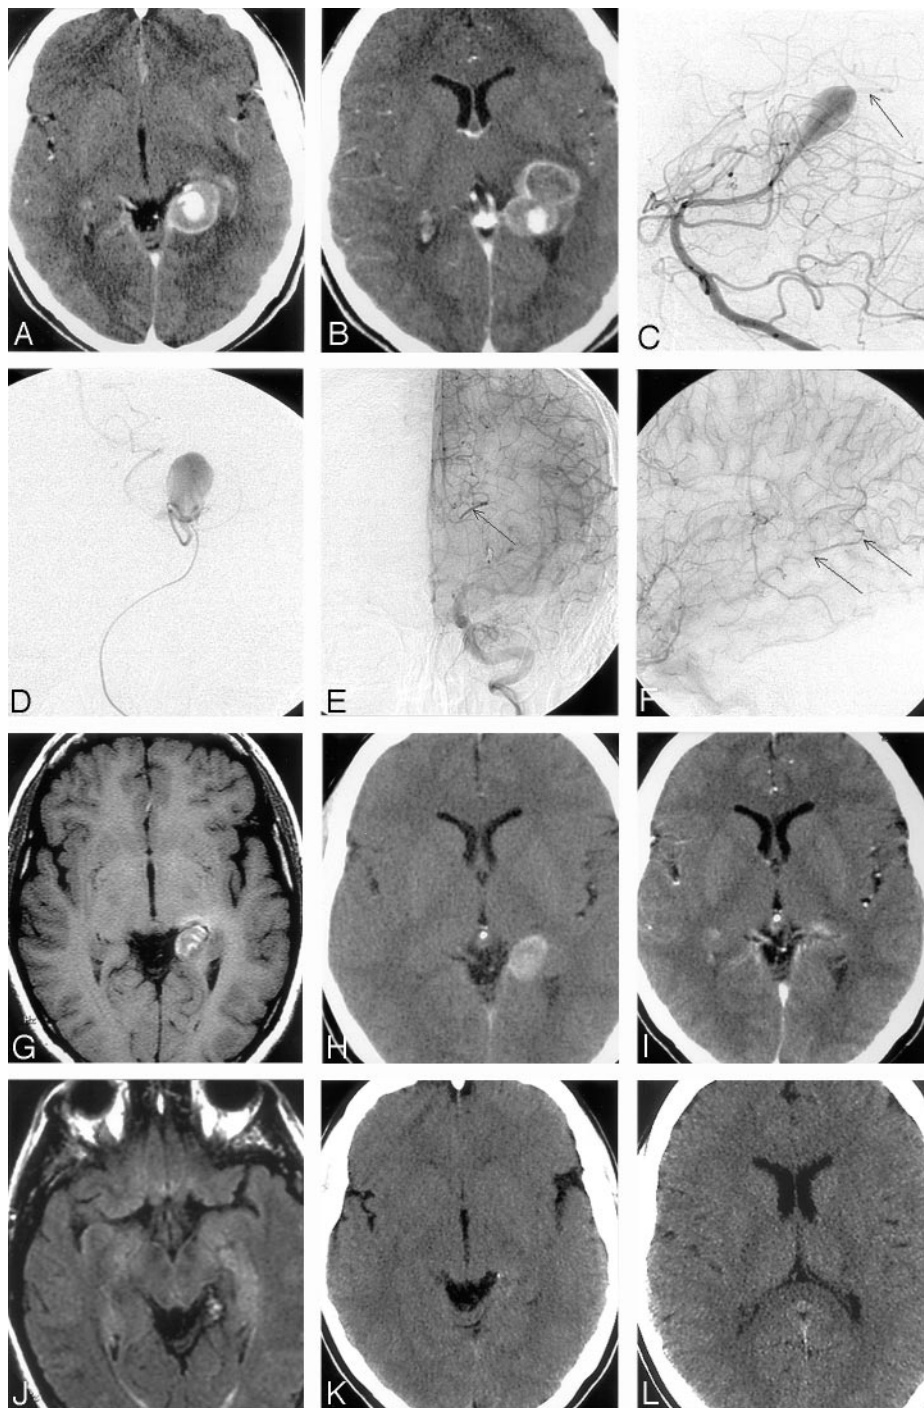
Partially thrombosed giant aneurysm of the P2-P3 segment of the left posterior cerebral artery in a 28-year-old woman presenting with headache and loss of consciousness. *A* and *B*, CT scans with injection of contrast show a large lesion compatible with the diagnosis of a thrombosed aneurysm. *C*, Oblique view of the left vertebral artery angiography shows the circulating portion of the aneurysm associated with a slight stenosis of the parent artery. Slow filling of the parent artery beyond the aneurysm is noted (*arrow*). *D*, Intermediate step of the endovascular procedure. After occlusion of the P2-P3 segment of the posterior cerebral artery by using coils, anteroposterior (*E*) and lateral (*F*) views of the left internal carotid artery angiography show the retrograde vascularization of the PCA distal to the occlusion via the leptomeningeal anastomosis (*arrows*). Thirty-six hours after PAO, the patient presented with transient mild paresthesias and mild oculomotor paresis, which completely regressed in 3 days. Follow-up studies after 1 month (T1-weighted MR image, (*G*); and CT scan with injection of contrast, (*H*) show reduction of the aneurysmal thrombosed portion and reduction of the mass effect. Follow-up studies after 1 year (CT scan, (*I*) and after 4 years (fluid-attenuated inversion recovery MR image, (*J*); and CT scans, (*K* and *L*) show further shrinkage of the aneurysmal thrombosed compartment. The small left posterior thalamic infarct is well visualized (*L*). Findings of the neurologic examination were normal at 5-year follow-up.
